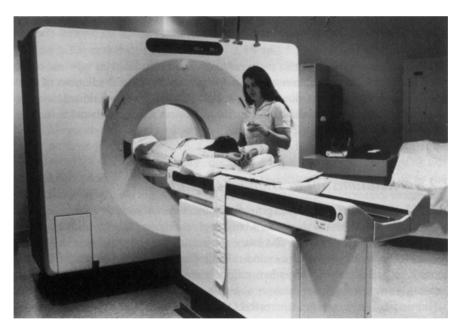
Advanced imaging device. Computed tomography (CT) scanners and other imaging devices used in radiology are of interest to both medical computer scientists and biomedical engineers. (Photograph courtesy of Janice Anne Rohn.)
